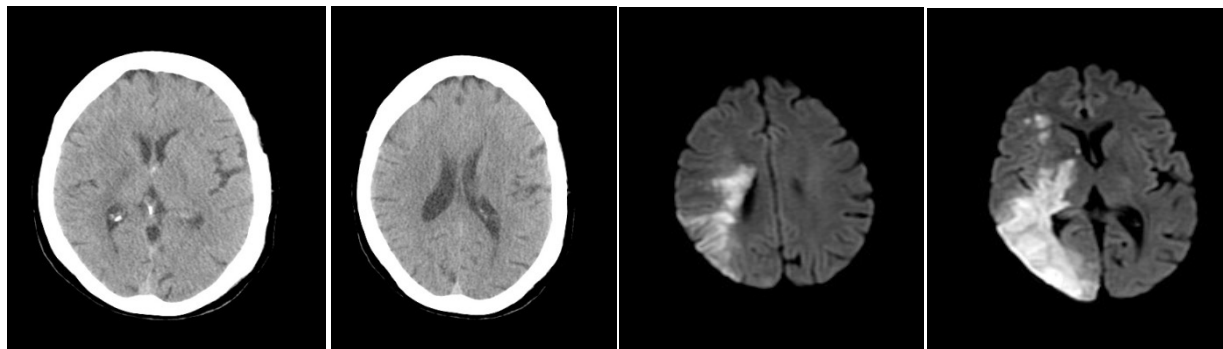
NCCT and MRI-DWI brain image shows different ASPECT score in same patient with subtle hypodensity in NCCT with involvement of internal capsule only , while in DWI , it shows restriction in internal capsule, lentiform nucleus, M1, M3, M5 and M6 area as per ASPECT distribution in MCA artery distribution in a patient of hemiparesis.
